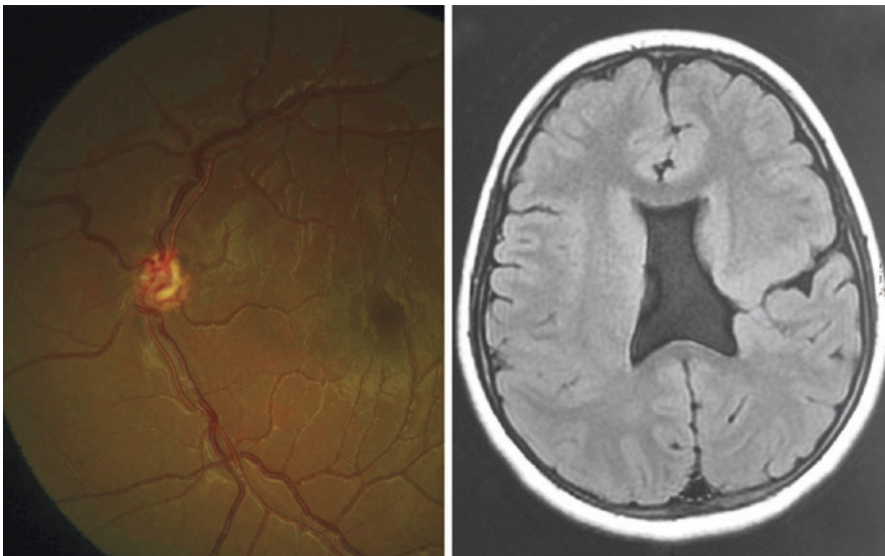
A child with bilateral optic nerve hypoplasia—the left optic nerve—shows a smaller diameter, with a ‘double ring’ and increased tortuosity of the retinal vasculature. This child was found to have an absent septum pellucidum as seen in the MRI image
